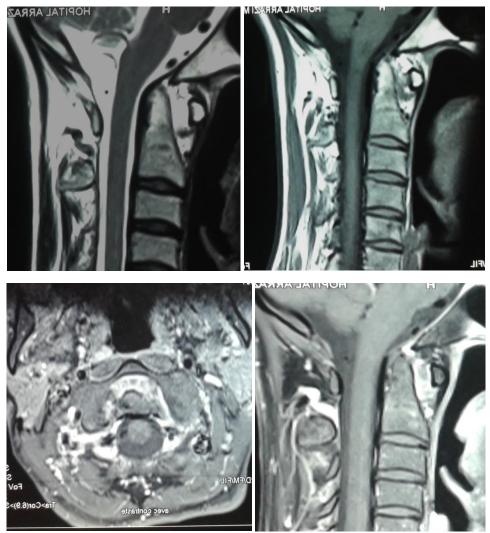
MRI in sagittal T2-weighted (a), T1-weighted (b) and gadolinium-injected sagittal (c) and axial (d) sections
